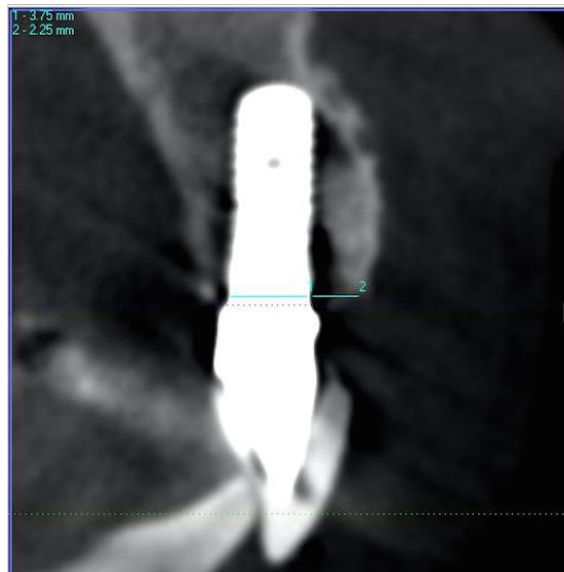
The labial bone thickness measured by CBCT.
